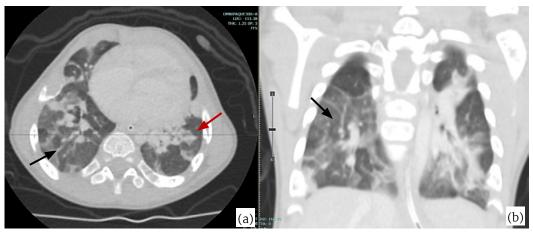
A 14-year-old boy with deep venous thrombosis of the left internal iliac artery developed progressive legs edema, dyspnea and hemoptysis. The axial and coronal chest CT scan showed air bronchogram in consolidation at the posterior basal segments of LLL (black arrows) (a, b), and a suspected infarction. The massive tumor thrombus was seen in the left main pulmonary artery in axial and coronal views (white arrow) (c, d).
